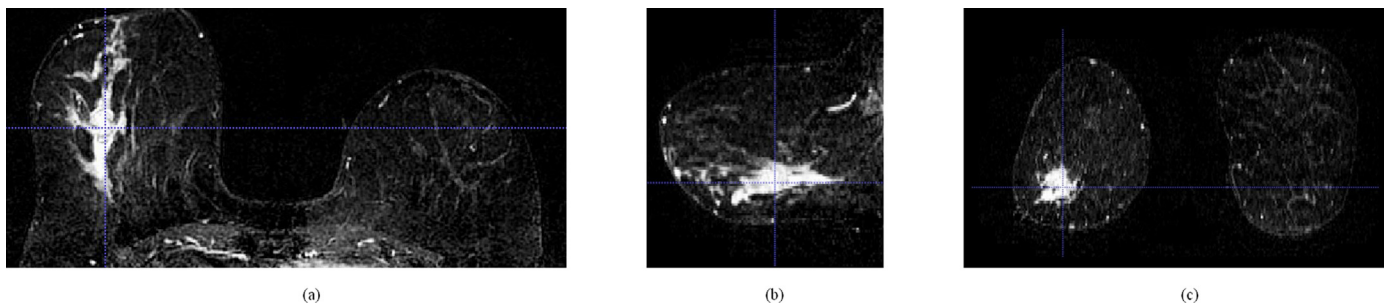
Sample T2-weighted MRI displaying Stage III from the TCGA-BRCA data set, (a) axial view, (b) sagittal view and, (c) coronal view.
